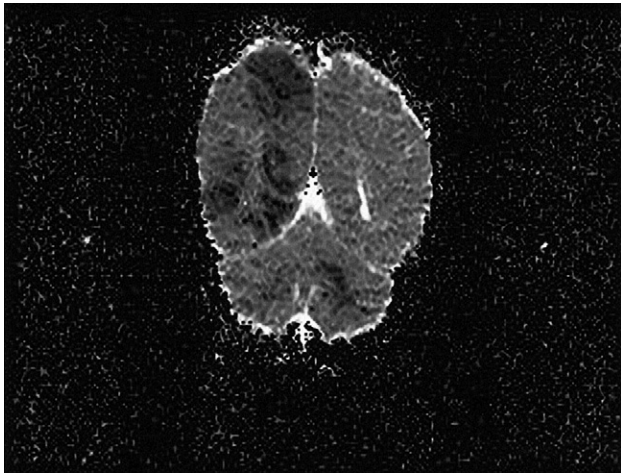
Apparent diffusion coefficient on diffusion-weighted magnetic resonance imaging performed 80 hours after presumed seizure onset reveals reduced diffusion (black) in right cortex and left cerebellum.
